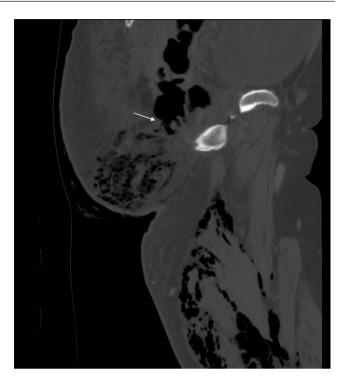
Contrast-enhanced CT of the upper leg, sagittal plane. The air extends upward into the soft tissues of the buttocks and continues into the retroperitoneum, where a rectal perforation is suspected (arrow)
